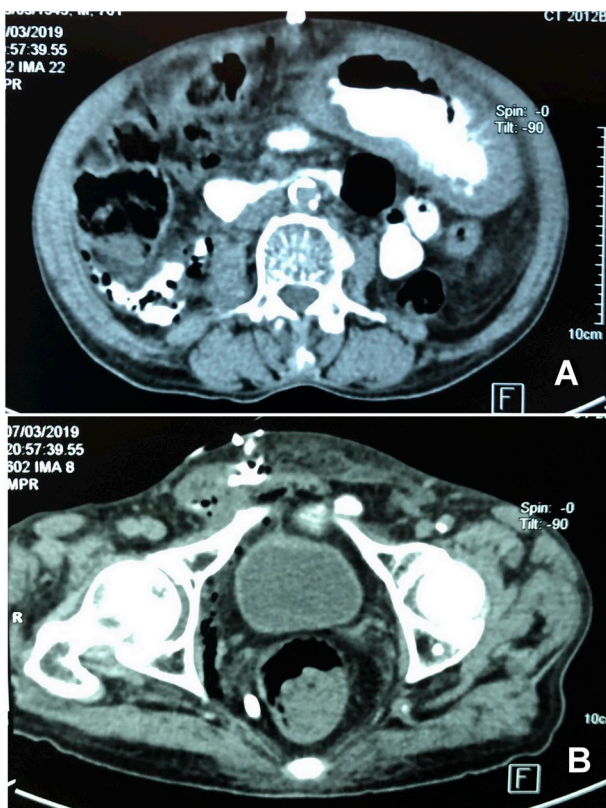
CT-scan of the abdomen with oral contrast showing the contrast media tracking outside the bowel and passing to the retroperitoneum and the right scrotum.
